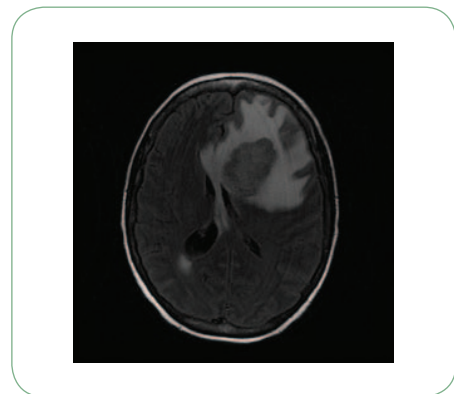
Brain MRI of woman with IBC who only complained of a headache when she received antiemetics after chemotherapy.
